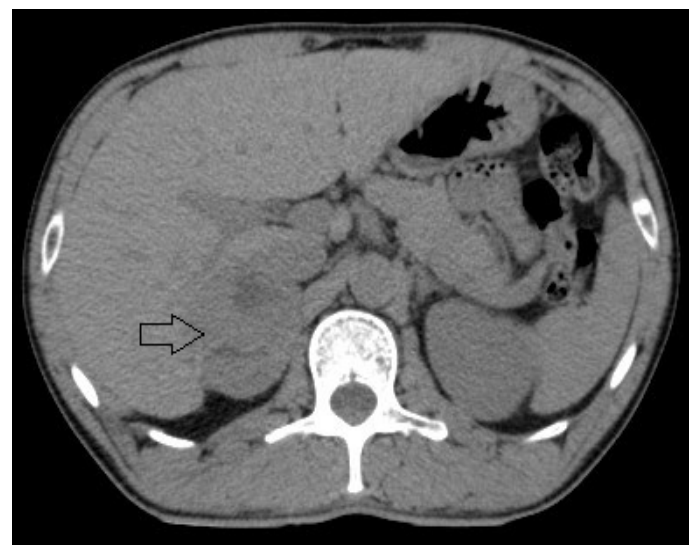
Plain CT image of mass
